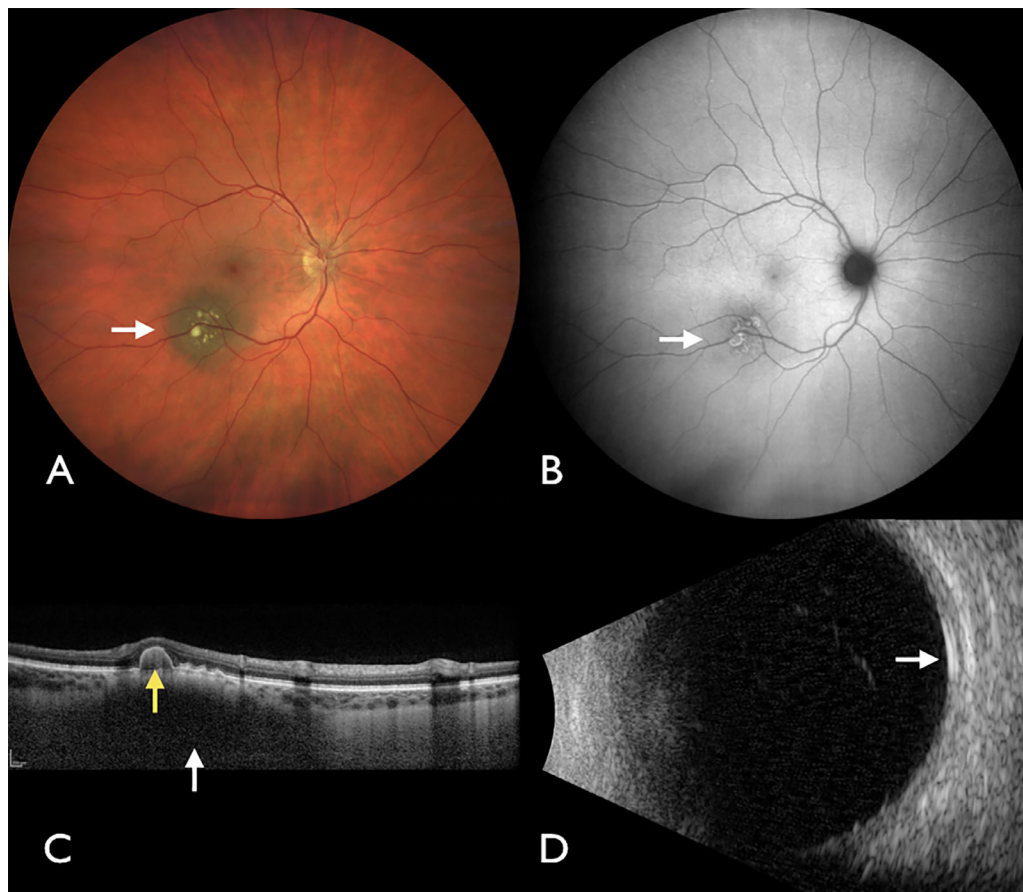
Multimodal imaging of benign choroidal nevus. (A) Choroidal nevus (arrow) with overlying yellow drusen. (B) Autofluorescence demonstrating the ring-shaped, minimally bright signal (arrow) of drusen. (C) OCT showing dark nevus with low signal (white arrow) and overlying pigment epithelial detachment (yellow arrow). (D) Ultrasound examination showing flat nevus (arrow) with <2 mm thickness.
